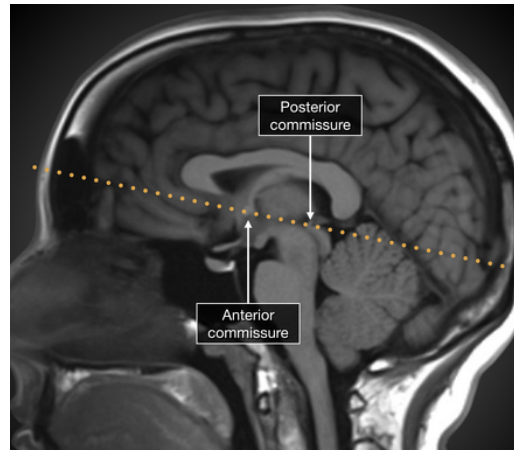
AC-PC line seen in an axial MRI image [47]
